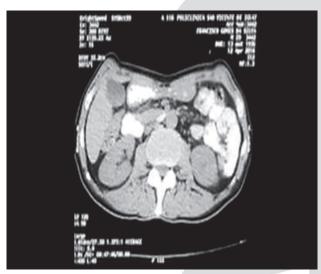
Computed tomography with oral contrast showing reduction in the superior mesenteric artery space and pinching of the third part of the duodenum
